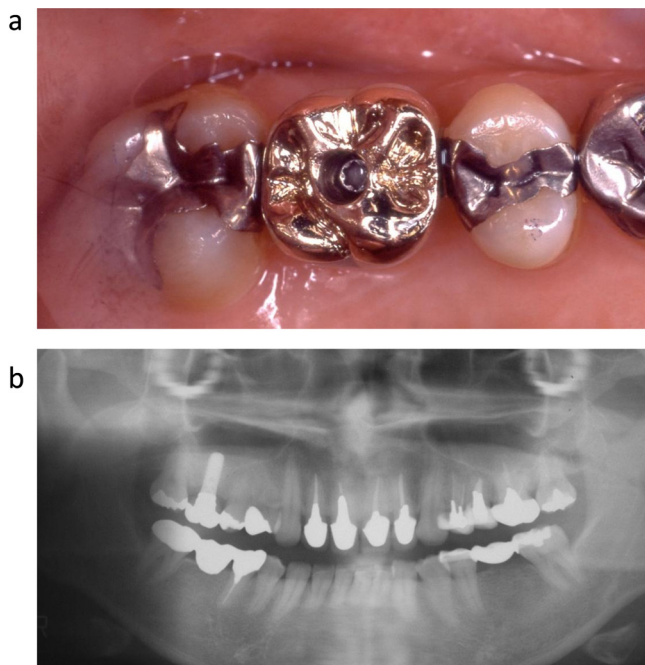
At the time of superstructure delivery. (a) Occlusal view and (b) panoramic radiograph.
